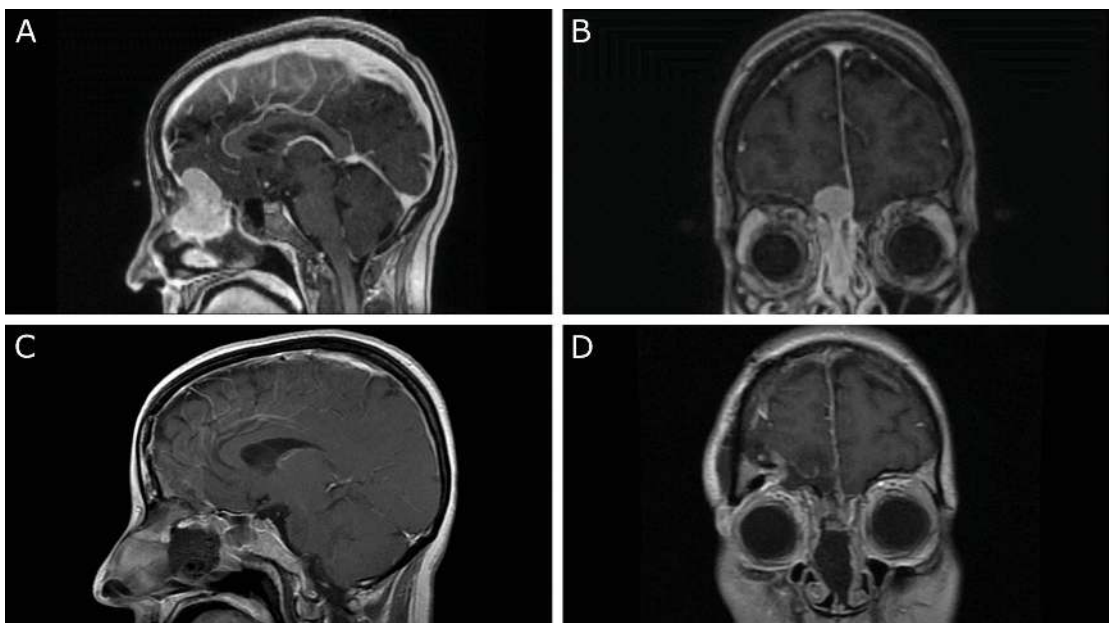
(A) Sagittal and (B) coronal view of a preoperative T1-weighted post-contrast image depicting a large enhancing mass compatible with an olfactory groove meningioma. The tumor extended far anterior against the frontal sinuses with extension into the nasal cavity. Patient underwent a combined approach. Postoperative post-contrast T1-weighted (C) sagittal and (D) coronal planes depict a complete resection.
